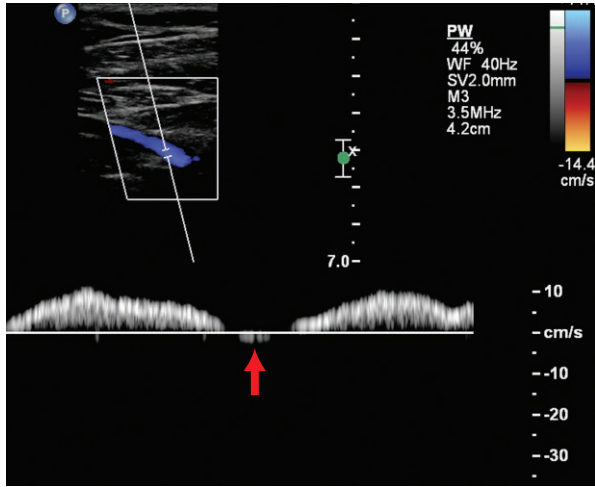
The common femoral vein is patent by color and demonstrates normal phasic variation on the spectral Doppler waveform. There is transient flow reversal (arrow) during breathing, which may be present normally, as it was in this case.
